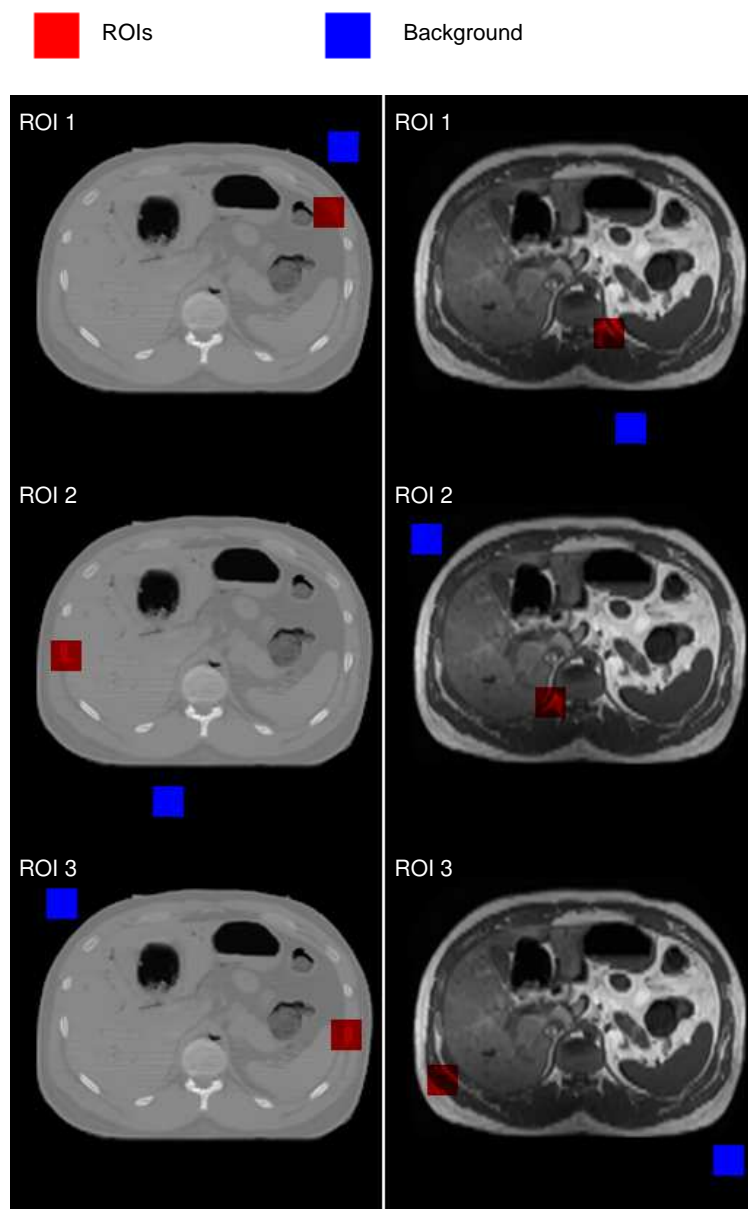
Three ROIs are chosen from both CT and MRI images. ROIs are highlighted in red, whereas regions of background are also chosen, but labeled in blue. The display window is $[0 \ 1]$.
